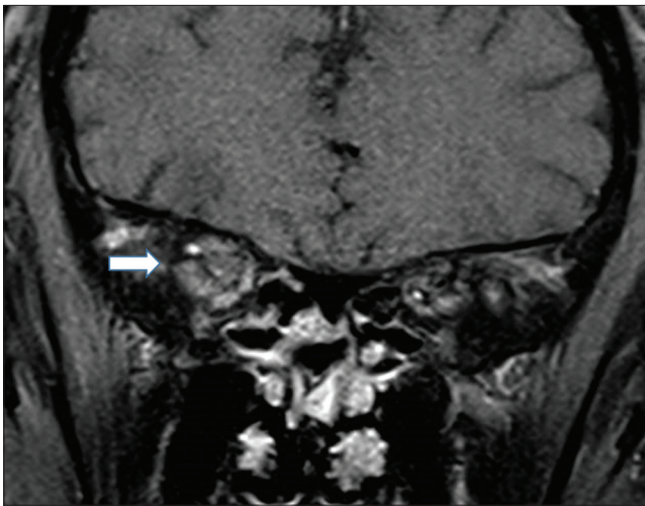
Magnetic resonance imaging, disclosing a crowded right orbital apex
